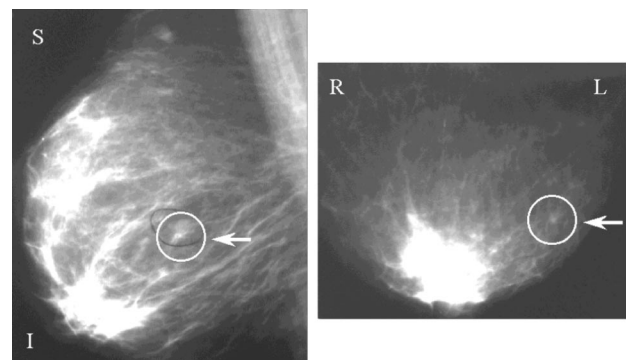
Mammograms of subjects: This picture shows the x-ray mammogram of the subject seen in Figures 7 and 8. The mammogram on the left is a medial lateral view of the breast showing the location of the lesion in the right breast. A circle and an arrow indicate the site of the tumor. Part of the pectoralis muscle is visible. The marks, "S" and "I" represent the superior and inferior sides, respectively. The cranio-caudal view of a mammogram is shown on the left. R and L on the picture represent right and left lateral sides of the breast. An arrow and circle also show the location of the tumor.
